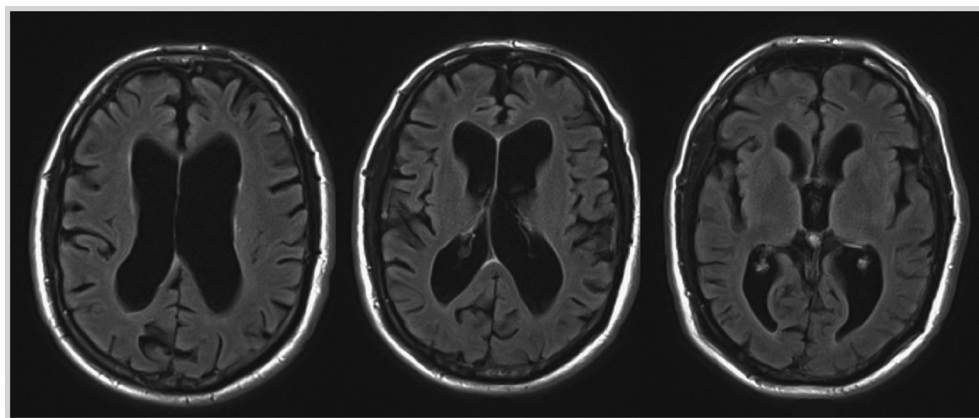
Imaging of the patient in Case 1-1. Axial fluid-attenuated inversion recovery (FLAIR) MRI showing minimal frontal and temporal lobe atrophy. There is also subcortical atrophy, characterized by enlarged ventricles.
